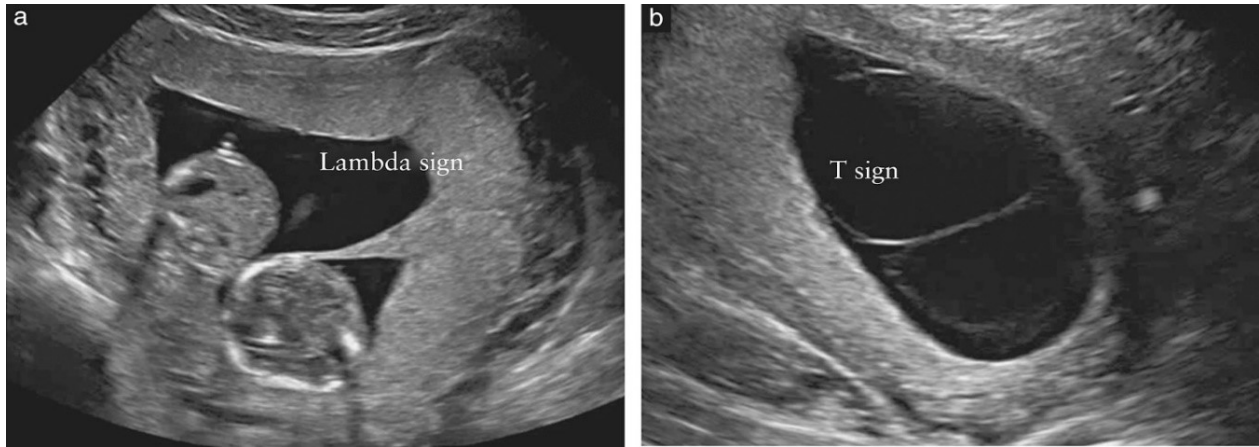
Ultrasound images showing (a) “lambda” or “twin peak” sign denoting a triangular extension of chorionic tissue from the placenta to the intertwin membrane, characteristic of a dichorionic twin pregnancy; (b) “T” sign denoting the formation of a right angle at the thin intertwin membrane and placental junction, characteristic of a monochorionic twin pregnancy.
